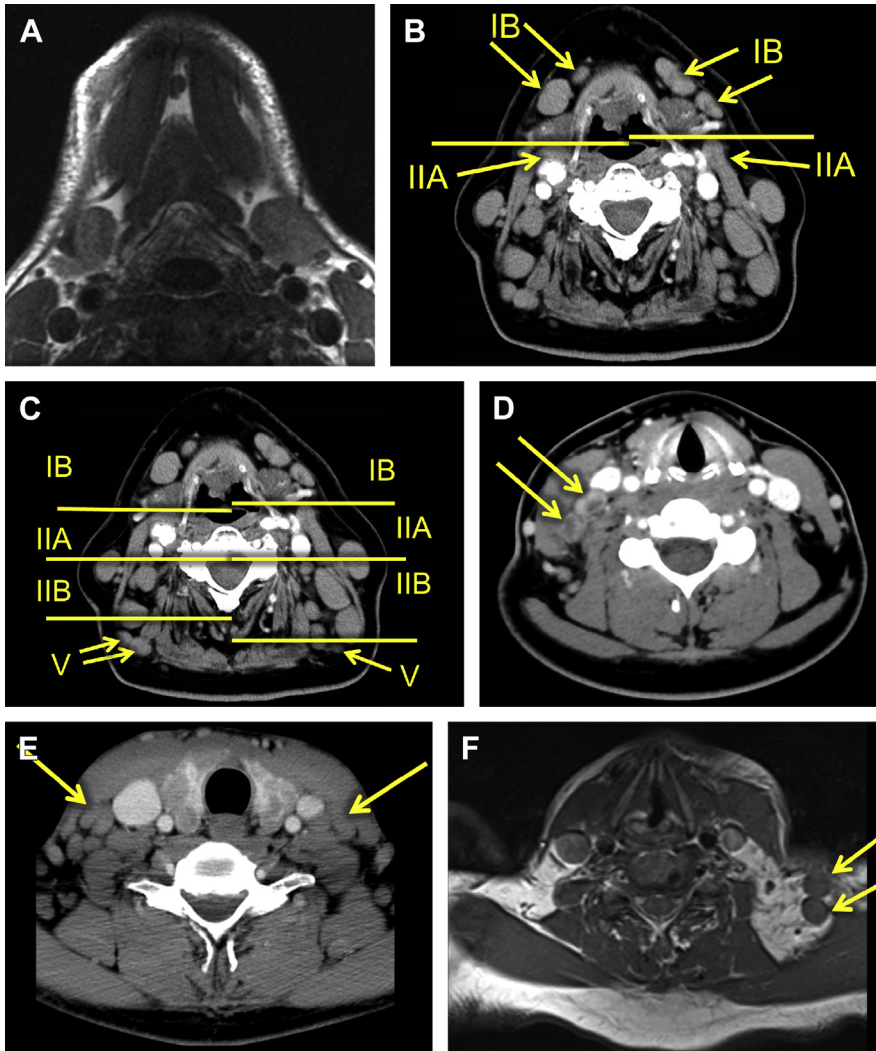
(A) Axial T1-weighted (T1WI) MR of level IA or submental lymph node between the anterior bellies of the digastric muscles. (B) Axial contrast-enhanced computed tomography (CECT) of level IB and IIA lymph node enlargement in a confirmed case of non-Hodgkin lymphoma. (C) Axial CECT of enlarged bilateral level IB, IIA, IIB and V lymph nodes in a confirmed case of non-Hodgkin lymphoma. (D) Axial CECT of necrotic, right level III lymph nodes (arrow) in a confirmed case of squamous cell carcinoma. (E) Axial CECT of level IV lymph nodes (arrow). (F) Axial TIWI MR with prominent left supraclavicular (transverse cervical chain) lymph nodes (arrow).
